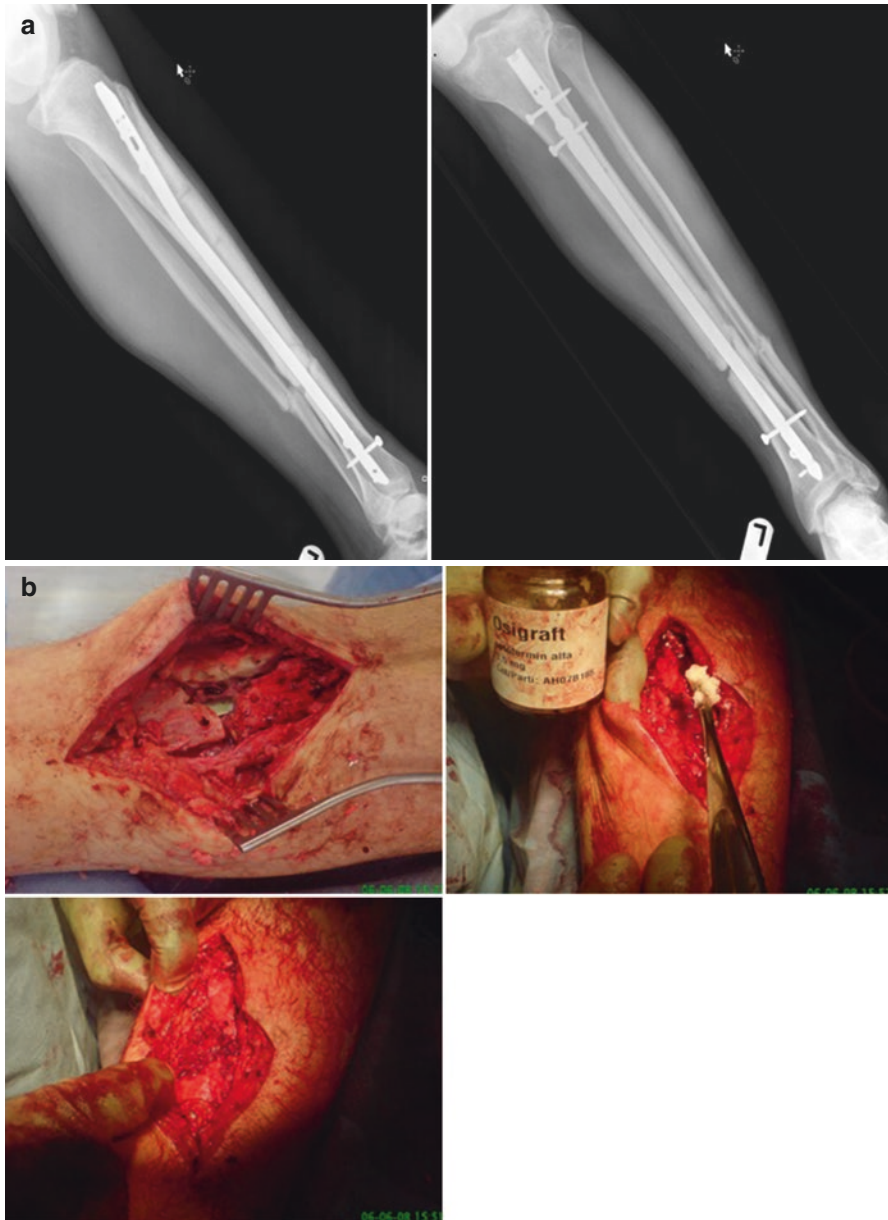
(a) Radiographs AP and lateral of left tibial fracture 9 months after fixation with intramedullary nail with no evidence of bone healing. (b) Intraoperative images demonstrating the fracture non-union and the implantation of BMP-7. (c) Radiographs AP and lateral demonstrating fracture union 4 months later
